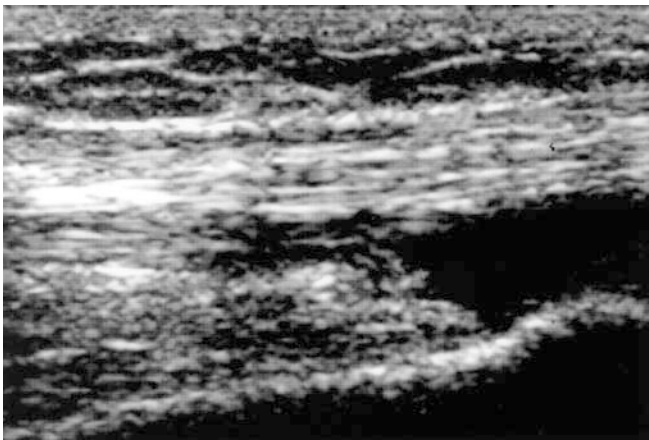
Sonography of the right knee revealing joint effusion and mild proliferation of the synovial membrane
